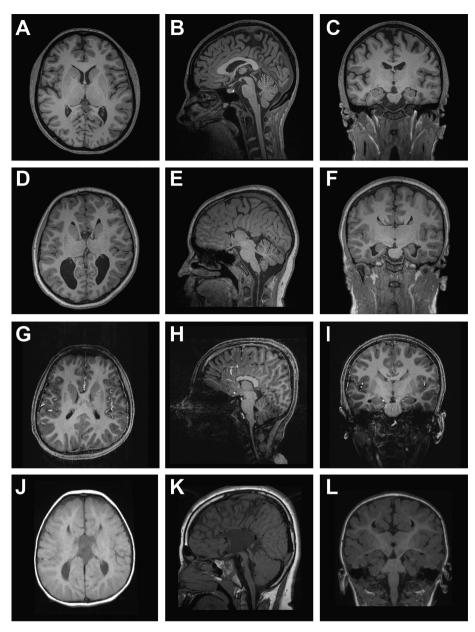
Axial MRI of control (A) and individuals with complete DCC-iACC (D), partial DCC-iACC (G) and DSBS (J). Midsagittal MRI of control (B) and individuals with complete DCC-iACC (E), partial DCC-iACC with absence of the rostrum and genu (H) and DSBS (K). Coronal MRI of control (C) and individuals with complete DCC-iACC (F), partial DCC-iACC (I), and DSBS (L). iACC, isolated agenesis of the corpus callosum; DSBS, developmental split brain syndrome. Images A–I adapted from Marsh et al. (2017). Images J–L adapted from Jamuar et al. (2017)
